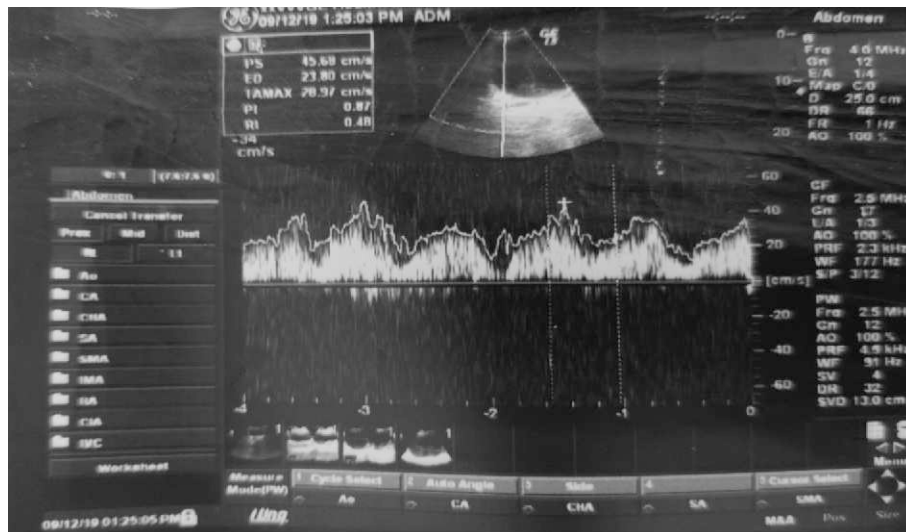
USG Color Doppler showed maintained vascularity.
